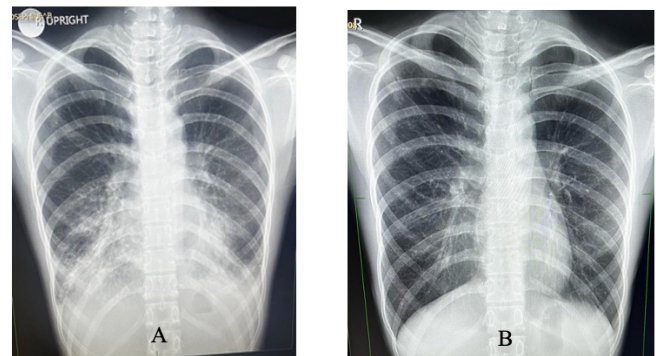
Chest x-ray of a 16-year-old female with pulmonary paragonimiasis; A) before and B) 1 month after praziquantel treatment
